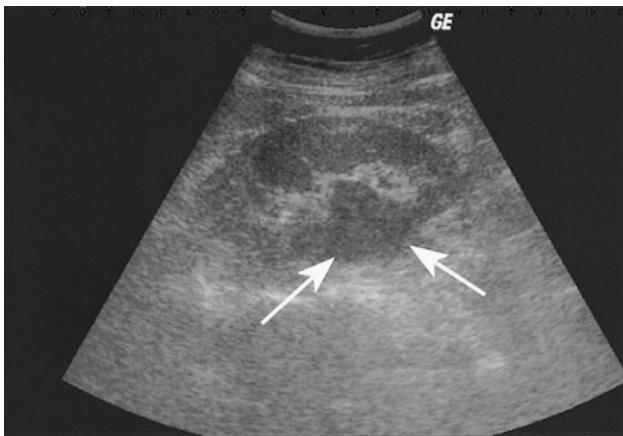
Abdominal sonogram reveals an anechoic area in the left kidney (arrows). Either hydronephrosis or a cyst should be considered.
